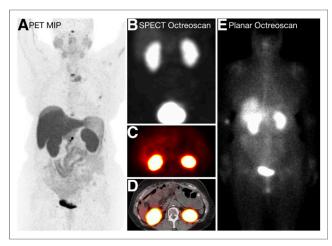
Example of SSTR PET demonstrating higher Krenning score than ¹¹¹In-pentetreotide in low-volume disease. This patient was graded as having Krenning score of 4 on SSTR PET (A) but 0 on SPECT (B–D) and planar imaging (E). Extent of disease was graded as 1 by 3 readers (e.g., 1–3 lesions smaller than 2 cm). MIP = maximum-intensity projection.
